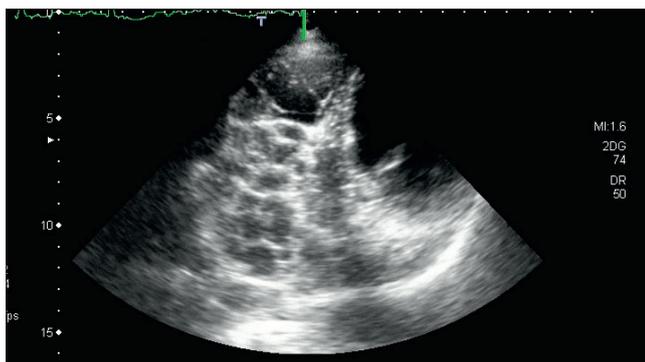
Transthoracic echocardiography, parasternal short view. The pathological structure in pericardium
